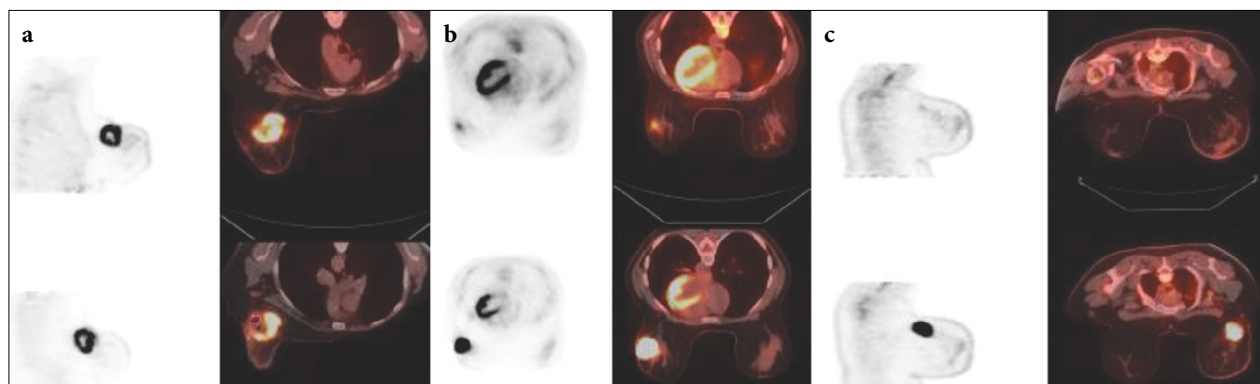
(a-c) Fifty-seven years old, left breast invasive ductal carcinoma, Grade 3, TN, baseline PET/CT (bottom row) tumor size 65×62×55 mm, SUV_{max} : 18.6. After two cycles of chemotherapy, the tumor size decreased to 38×43×42 mm and SUV_{max} to 11.2 on PET/CT (upper row) (a), 43 years old, left invasive ductal carcinoma, Grade 3, TN, baseline PET/CT (bottom row) tumor size 40×33×38 mm, SUV_{max} : 21.2, tumor size regressed to 15×14×9 mm and SUV_{max} : 2 after two cycles of chemotherapy (upper row) (b), 54 years old, right breast invasive ductal carcinoma, Grade 3, ER-, PR-, HER2+, tumor size in baseline PET/CT (bottom row) 47×35×41 mm, SUV_{max} : 16.7, tumor completely disappeared after two cures of chemotherapy (upper row). Surgical outcome: No residual tumor was observed (c). PET/CT: Positron emission tomography/Computed tomography; TN: Triple negative; ER: Estrogen receptor; PR: Progesterone receptor; HER2: Human epidermal growth factor receptor-2.
